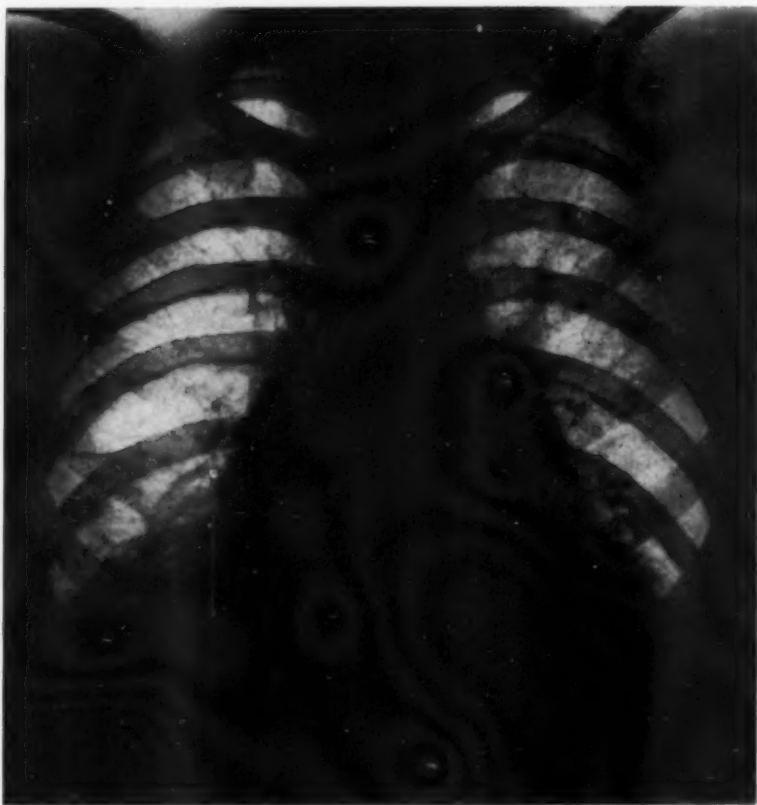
Roentgenogram (September 3). Ill defined densities in lower portions of both lung fields.
